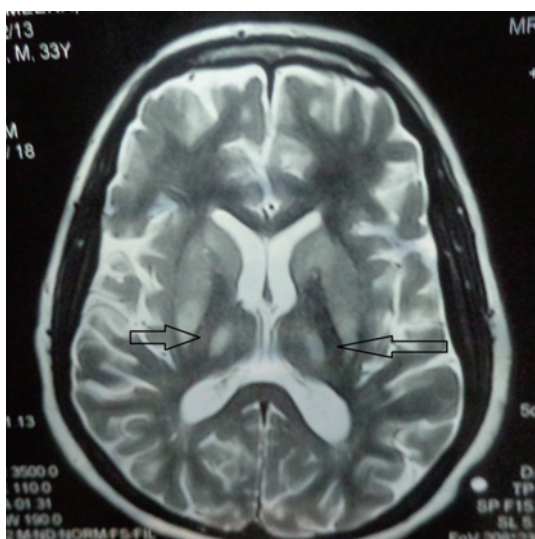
T2 weighted MRI of the brain showing hyperintense lesions in thalami.
